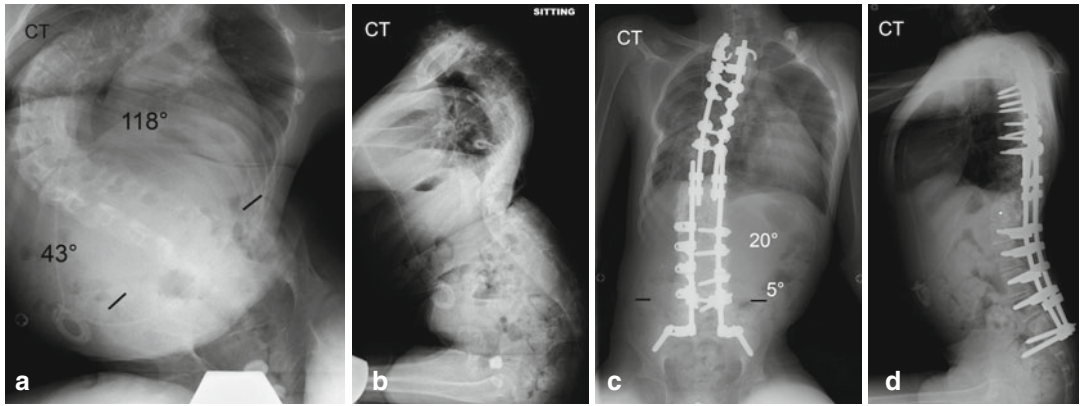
CT has a dramatic scoliosis of 118° and a pelvic obliquity of 43° (a, b). This is a rigid deformity that corrects at best on supine traction to 90°. The scoliosis and pelvic obliquity were corrected more than 80 % through a combination of spinal destabilization procedures that included anterior releases, vertebral column resection, and rib osteotomies, and rigid segmental instrumentation provided by pedicle fixation (c, d). Four
